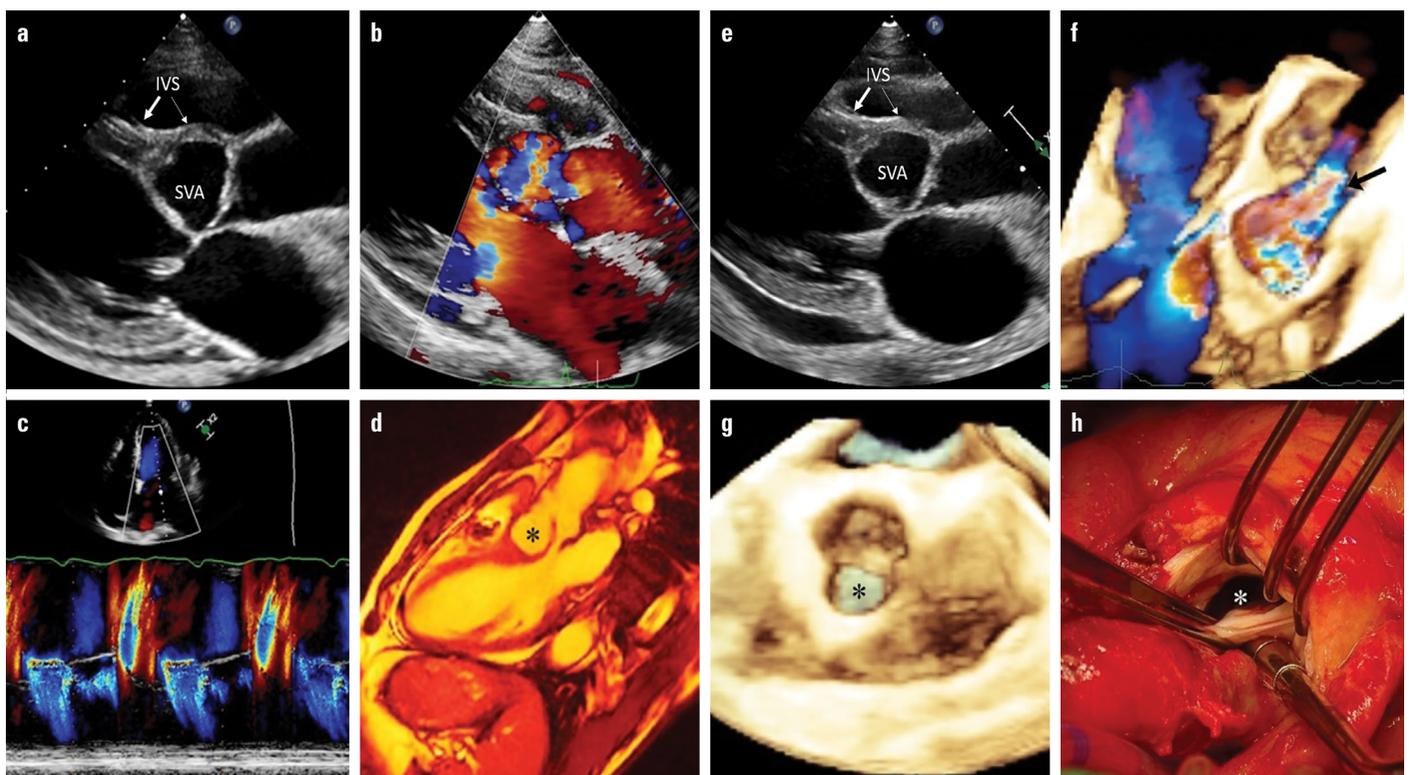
Long-axis transthoracic echocardiography (TTE) image showing the aneurysm bulging into the left ventricle dissecting into the interventricular septum (thin arrow) (a). Blood gushing into the aneurysm because of severe aortic regurgitation during diastole (b). Systole and diastole mitral regurgitation was observed using TTE color m-mode (c). Large sinus Valsalva aneurysm revealed by cardiac magnetic resonance imaging (*) as in TTE (d). Long-axis transthoracic echocardiography (TTE) image (taken during the second TTE examination) showing moderate pericardial effusion and a markedly dilated LV chamber size (e). Intraoperative 3D transesophageal echocardiography (TEE) image showing the aneurysm inlet (black arrow) and diastolic flow filling up the inlet (f). A 3D TEE image reveals that the sinus Valsalva aneurysm (SVA) originated from the right coronary sinus (*) (g). Intraoperative view of the SVA inlet (*) (h)
